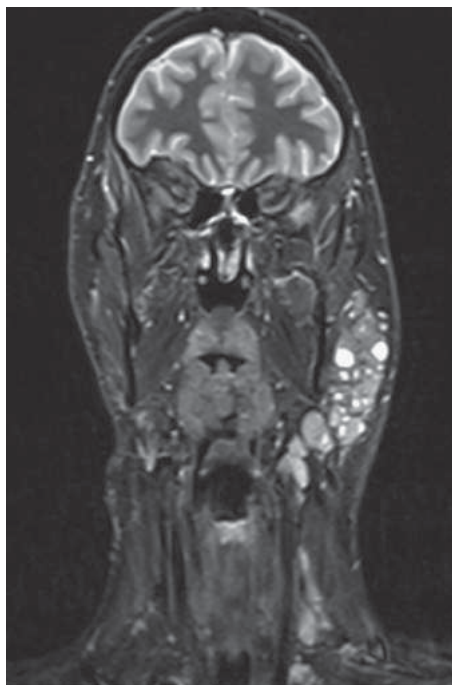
MRI image of a Sjögren's patient showing an enlarged left parotid gland with cyst-like lesions.
